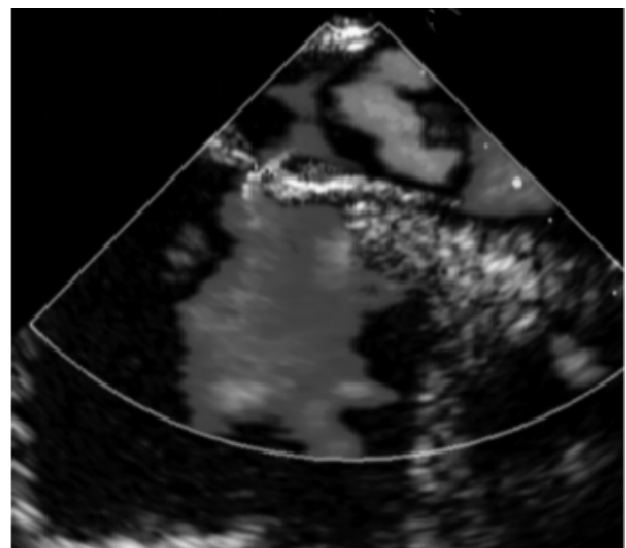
Transesophageal echocardiography suggested PFO (the diameter of foramen ovale: 1.9 mm).
